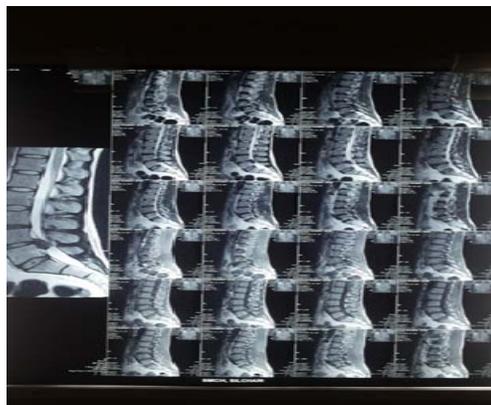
T2W MRI sagittal view showing prolapsed.
